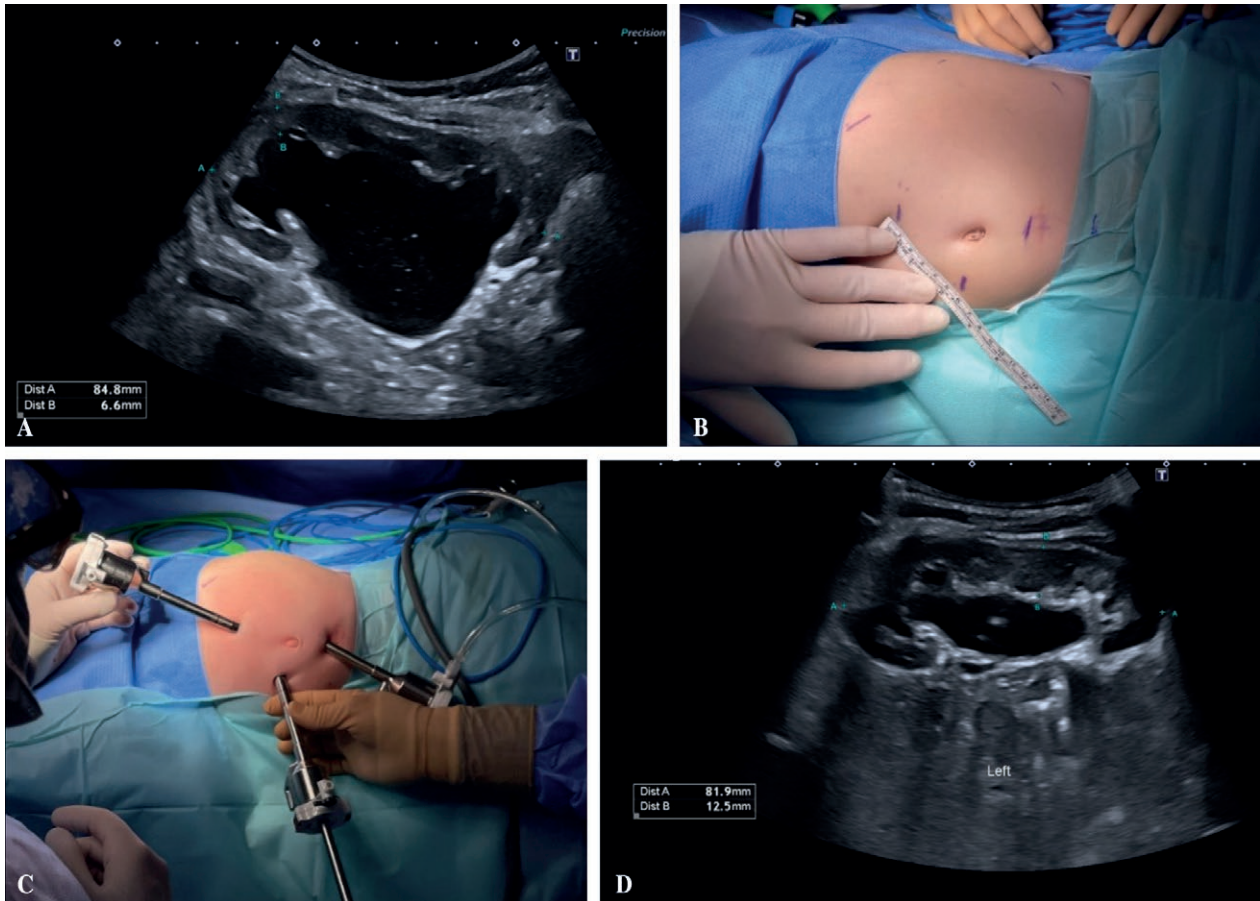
7-month-old patient with left ureteropelvic stenosis (A). Measurement of the minimum distance between ports greater than 4 cm (B). Placement of robotic ports for access to the left renal capsule (C). Ultrasonography of the ureteropelvic junction 3 months after ureteropyeloplasty (D).
